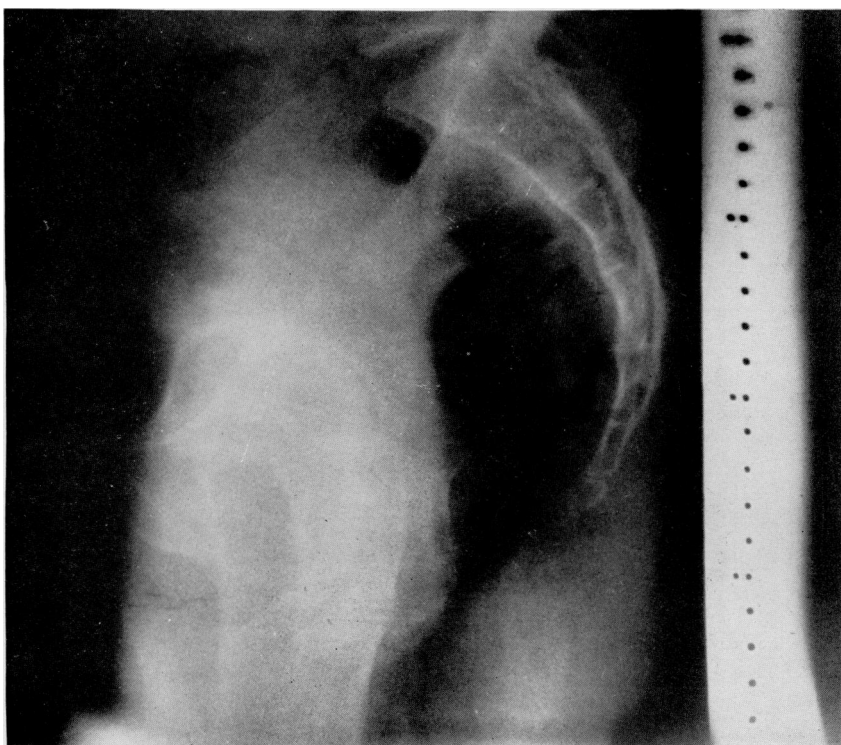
Lateral roentgenogram of pelvis. The scale shows corrected centimeters in the sagittal plane. All measurements shown in Fig. 2 may be measured in this view.
